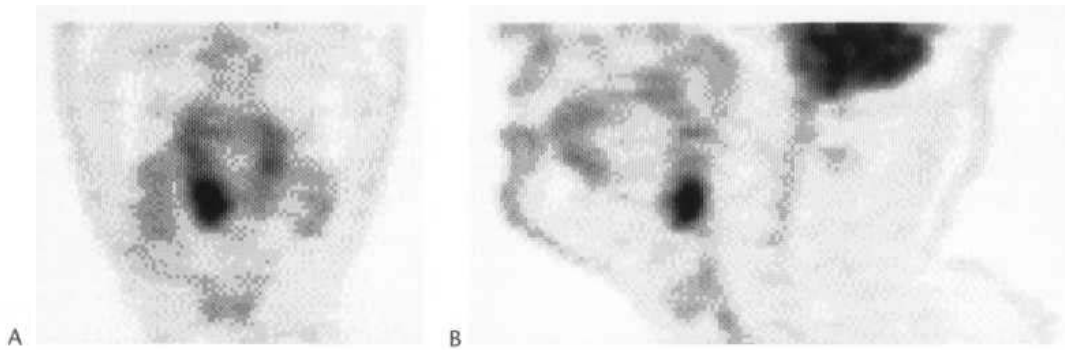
FDG-PET axial (A) and sagittal (B) images in a patient with a small primary carcinoma arising in the vallecula. (Courtesy of Dr P. Julyan, Christie Hospital, Manchester.)
